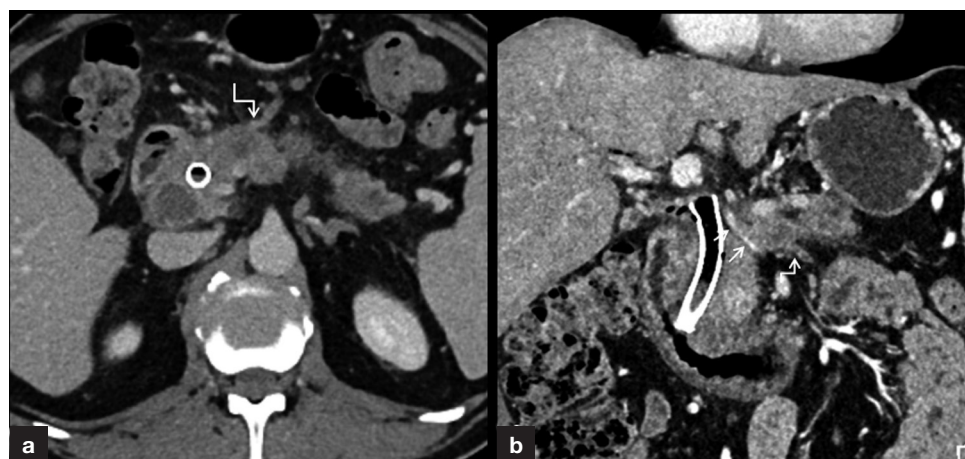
Pancreatic adenocarcinoma with unresectable venous encasement. Post-contrast computed tomography (a) axial and (b) coronal images show extensive venous encasement with partial obliteration of the main portal vein (straight arrows). The superior mesenteric vein is obliterated and not seen opacified. The tumour also involves the first jejunal branch of superior mesenteric vein (elbow arrows), precluding resection.
